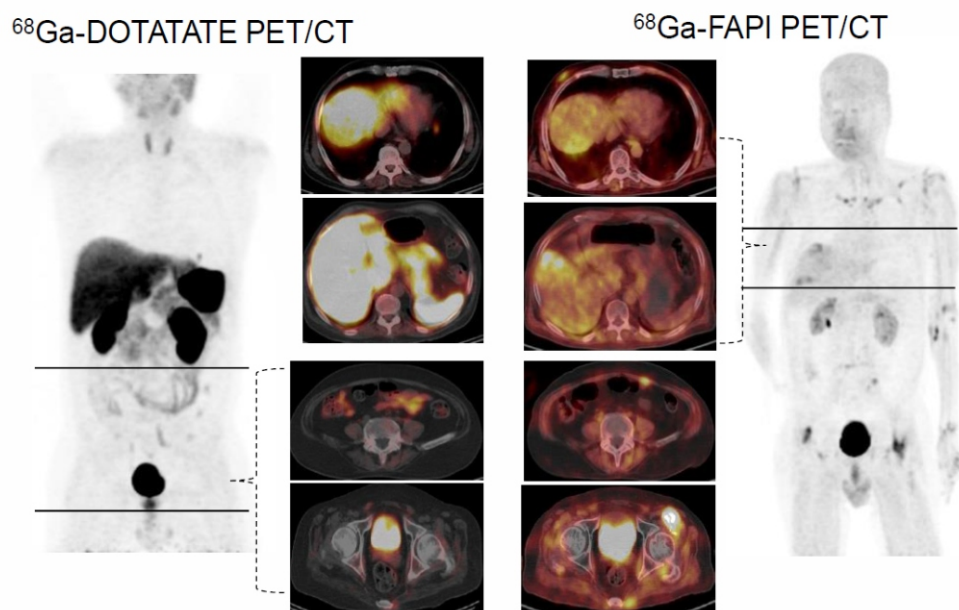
Representative MIP and the involved lesions on ^{68}Ga -DOTATATE (left) and ^{68}Ga -FAPI-46 (right) PET/CT scans of the same patient shown in Figure 8 with a history of GBM in the right frontotemporal lobes who underwent surgical resection and received radiotherapy.
